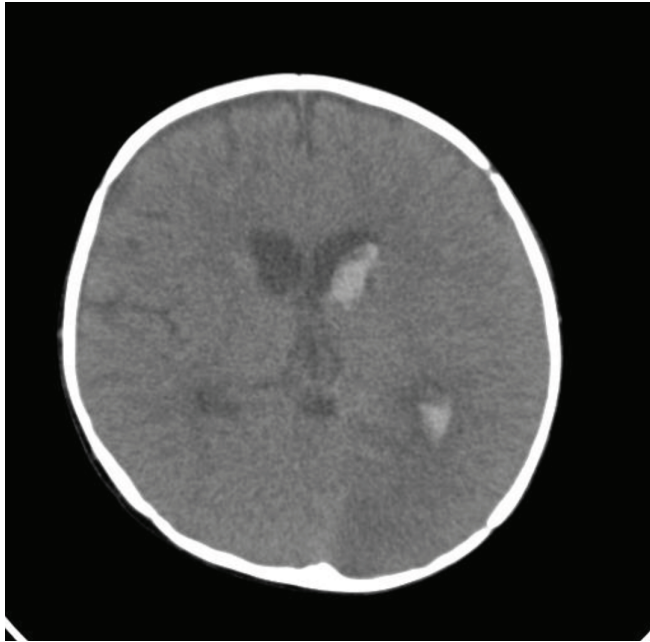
Brain computerized tomography (CT) scan and magnetic resonance imaging revealed left occipital subarachnoidal and intraventricular hemorrhage, left periventricular intracranial hemorrhage, and PCA infarct
